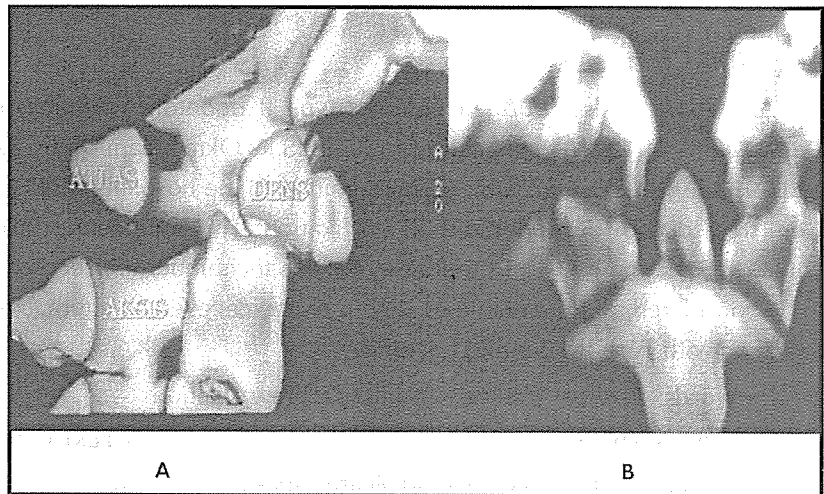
Type II odontoid fracture. A. Sagittal 3-D CT reconstruction. B. Coronal CT scan.
